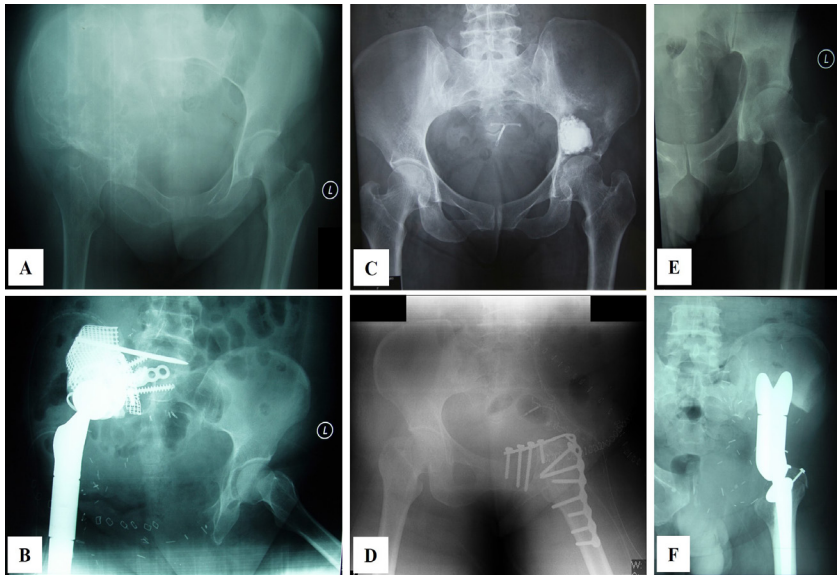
Reconstruction techniques following internal hemipelvectomy for periacetabular chondrosarcoma. Preoperative and postoperative plain radiographs demonstrated three different reconstructive approaches: (A, B) Modified total hip replacement (Case #2), (C, D) hip transposition with fusion (Case #4), and (E, F) saddle endoprosthesis (Case #6)
